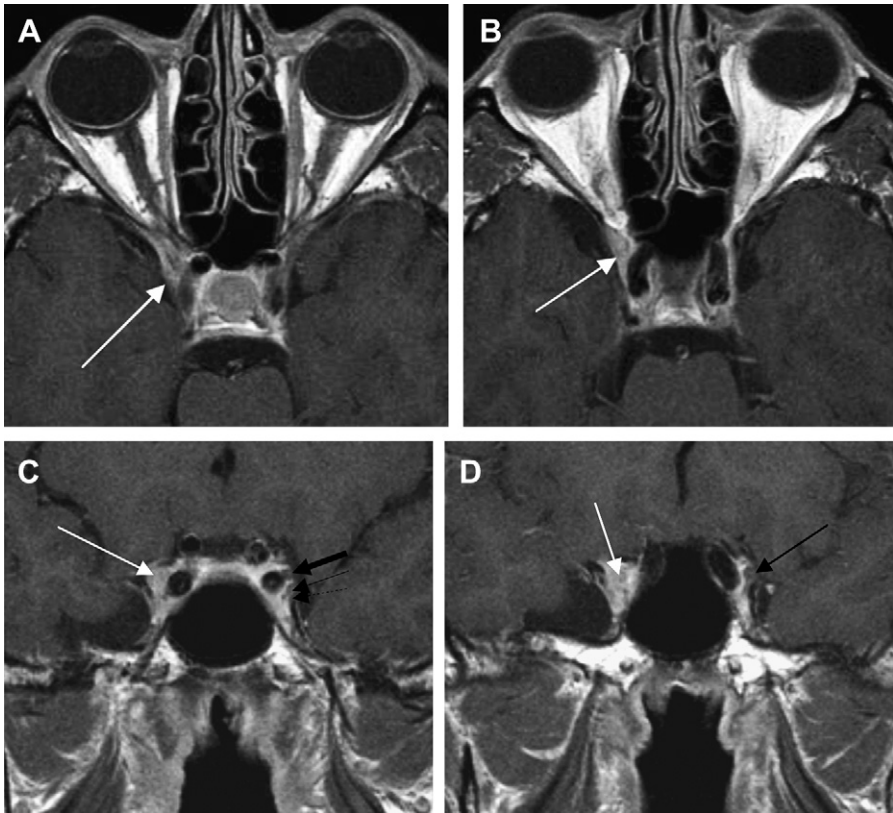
Post-gadolinium (A and B) and coronal (B and C) T1W MR images demonstrate soft tissue thickening and abnormal enhancement in the lateral wall of the right cavernous sinus, superior orbital fissure and optic canal (long white arrows in A–C). In (C) note cranial nerves III (thick black arrow), IV (thin black arrow), and V1 (dashed black arrow) in the lateral wall of the cavernous sinus on the left side, from superior to inferior. (D) On the affected side the nerves are enhancing and can hardly be recognized within the enhancing sinus (enhancing oculomotor nerve- short white arrow) (Tolosa-Hunt syndrome).
